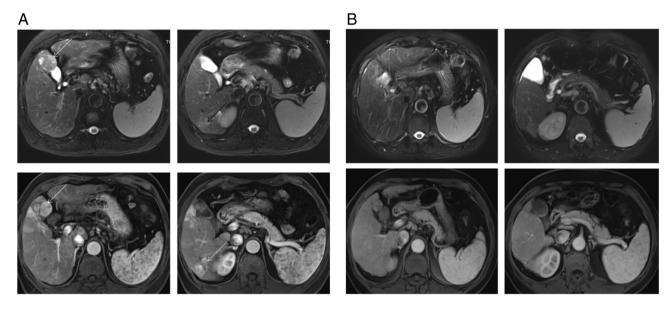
Imaging characteristics of the patient's liver. (A) MRI of the patient's liver before down-staging treatment. (B) MRI of the patient's liver after down-staging treatment. Arrows in the figure indicate the tumors.
